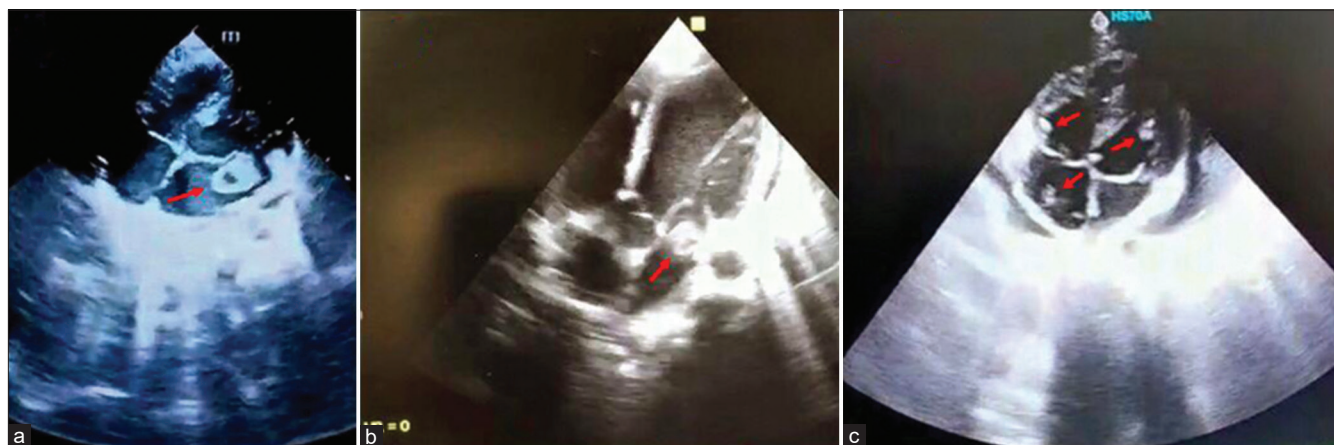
Transthoracic echocardiogram examination confirming a mobile mass in the left atrium that bonds to the posterior leaflet of the mitral valve (a), a large mobile mass in the left atrial chamber (b), and several uniform mobile masses in the right area of the heart and left ventricle (c) [22]
